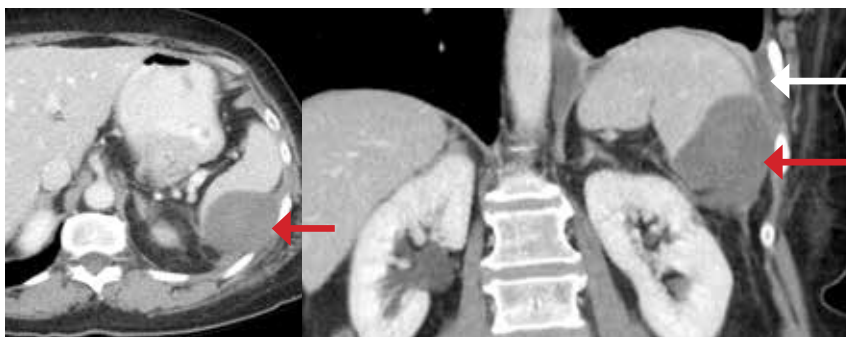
Follow-up contrast-enhanced CT (axial and coronal) shows the hypo-enhancing ablation zone without an enhancing residual tumor (red arrows). There is a small area of reactive left pleural effusion (white arrow) that is expected, following ablations adjacent to the diaphragm. The left renal margin adjacent to the ablation zone in the coronal image does not show significant cryoablation-related hypo-density, thus ensuring lack of significant renal parenchymal damage.
